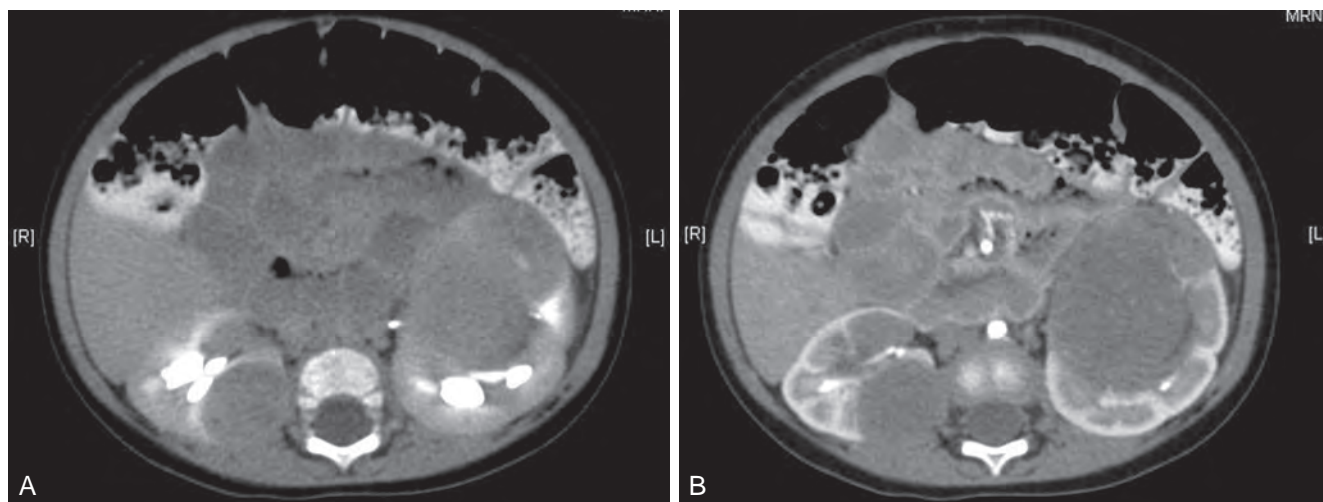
Patient with bilateral tumors who was treated with chemotherapy. A, Computed tomography (CT) before treatment. B, CT after 12 weeks of chemotherapy, revealing only minimal decrease in the size of the tumors. Bilateral partial nephrectomies were performed, revealing mature tumor elements with rhabdomyoblastic differentiation.
